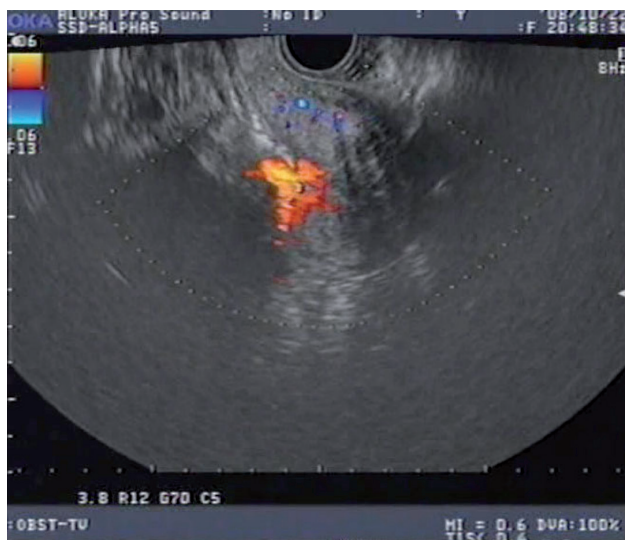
Ultrasound imaging of endometrium during MEA. Colored area (arrow) indicates an irradiated site during ablation of endometrium.
